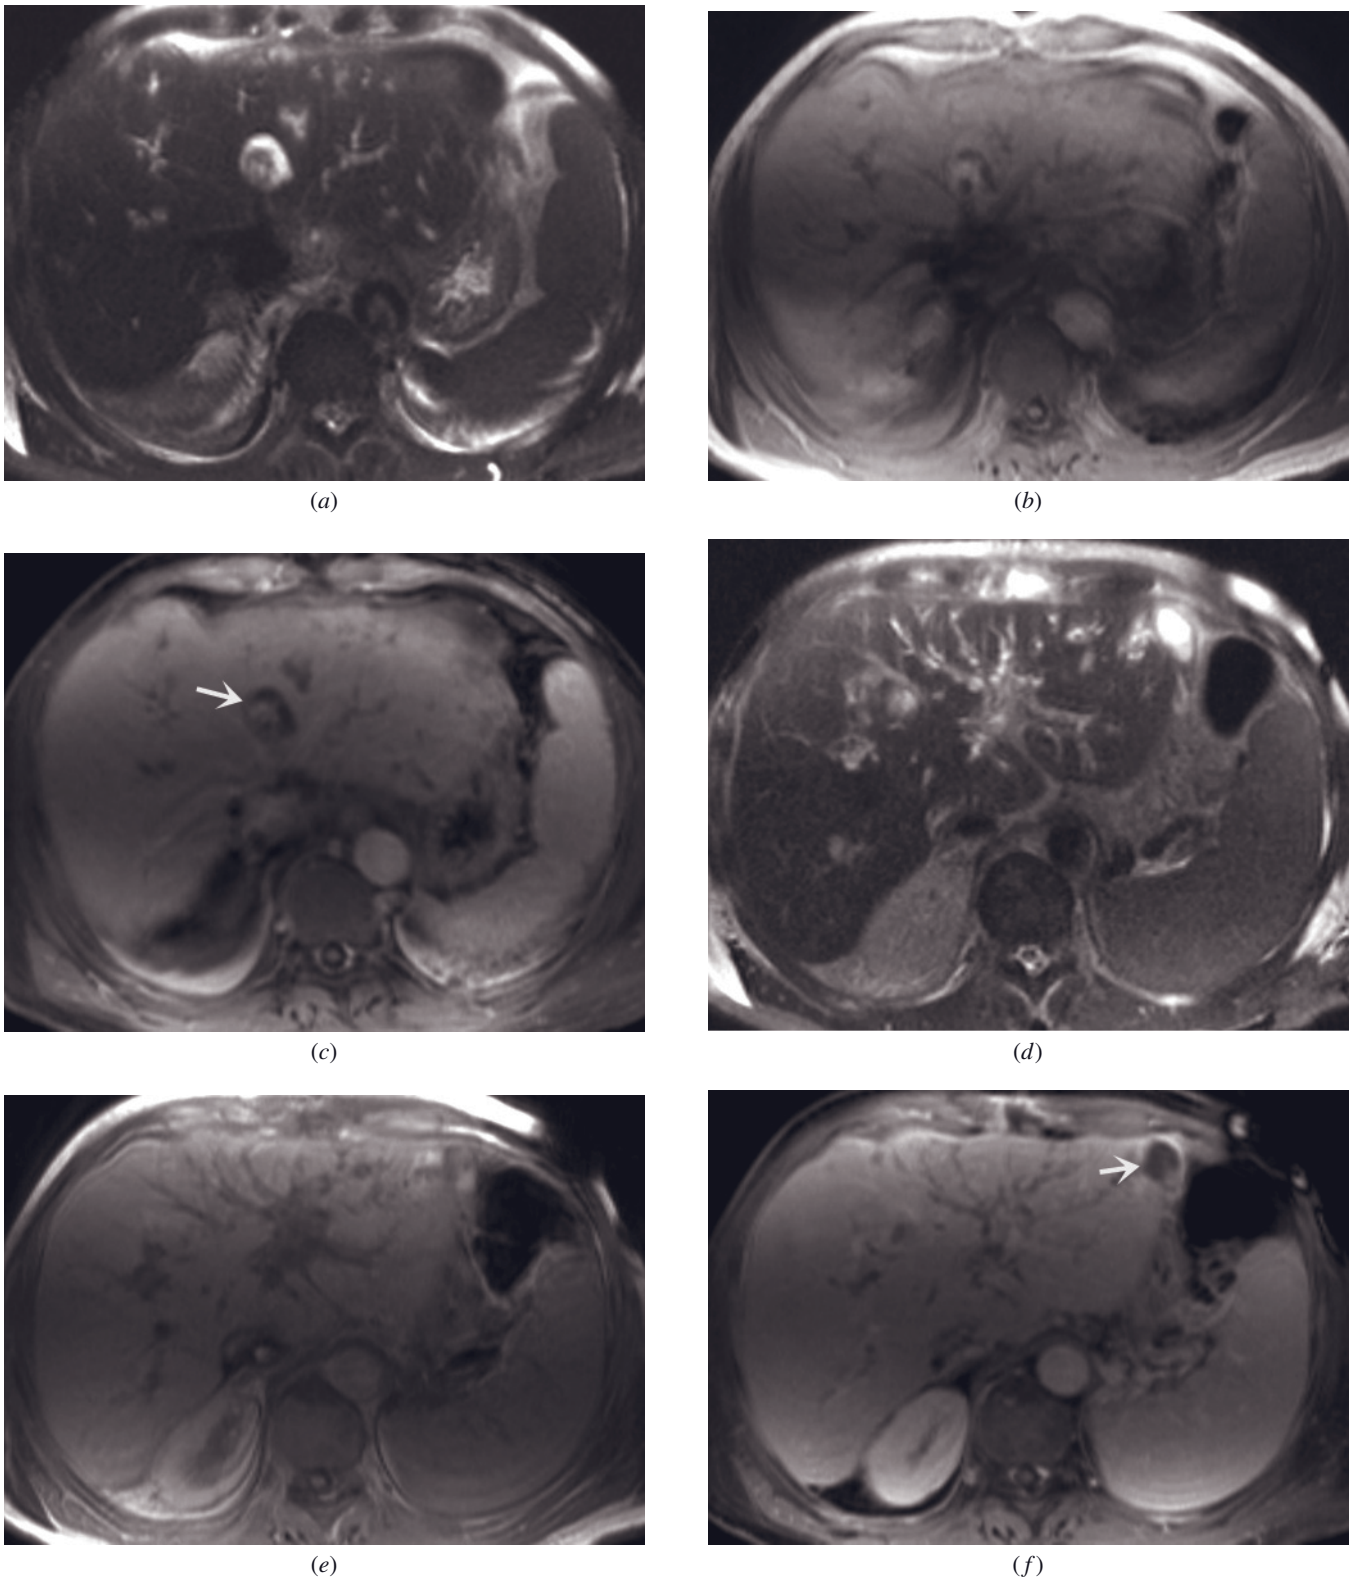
Fungus infection after liver transplant. T2-weighted SS-ETSE (*a, d*), SGE (*b, e*), and 90-s fat-suppressed (*c, f*) postgadolinium SGE images in the same patient at two different tomographic levels. There are two cystic lesions (arrow, *c, f*) in the left hepatic lobe that demonstrate a small focus of internal debris. Note the presence of mild biliary dilatation and ascites.
